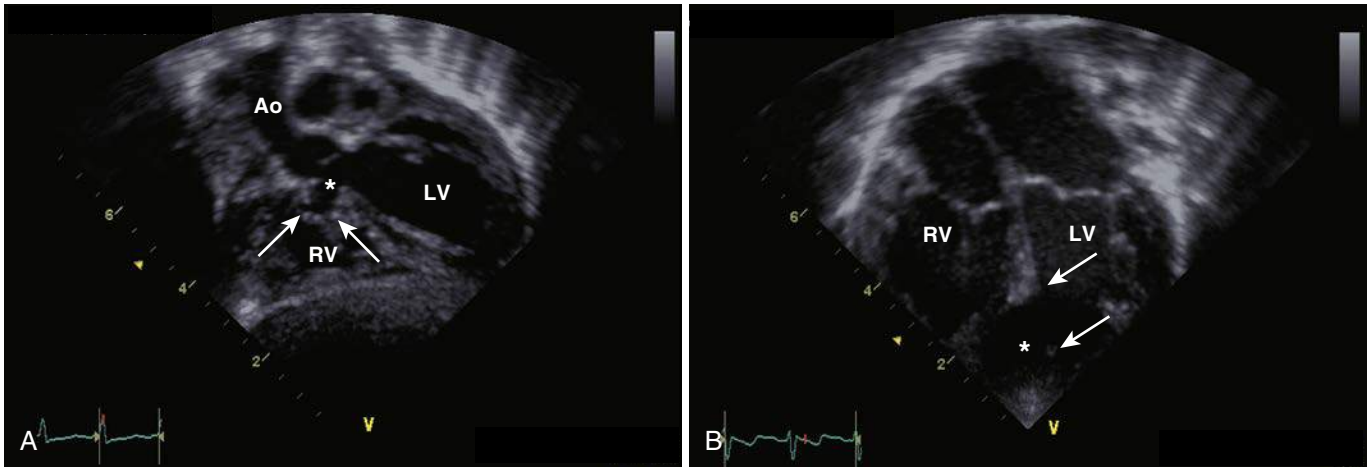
Echocardiogram showing a perimembranous ventricular septal defect (VSD), subcostal long-axis view (A), and a large trabecular muscular VSD, apical 4-chamber view (B). Arrows point to the edges of the defect. The defects are marked with asterisks. The perimembranous VSD is partially occluded by tricuspid valve tissue (arrows). Ao, Ascending aorta; LV, left ventricle; RV, right ventricle.
